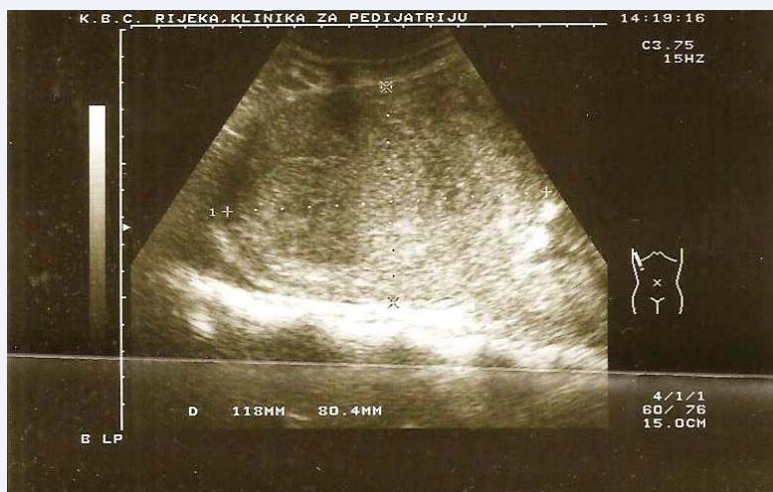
Abdominal ultrasound suggestive of heterogeneous liver lesion, measuring 12x8 cm.
